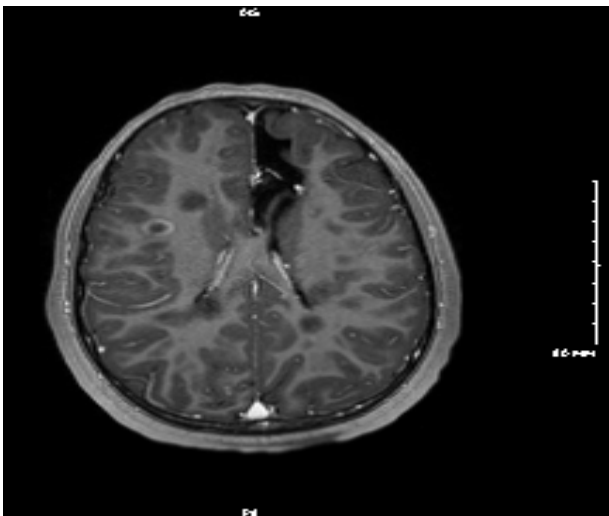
MRI brain “suggesting” a scolex.
